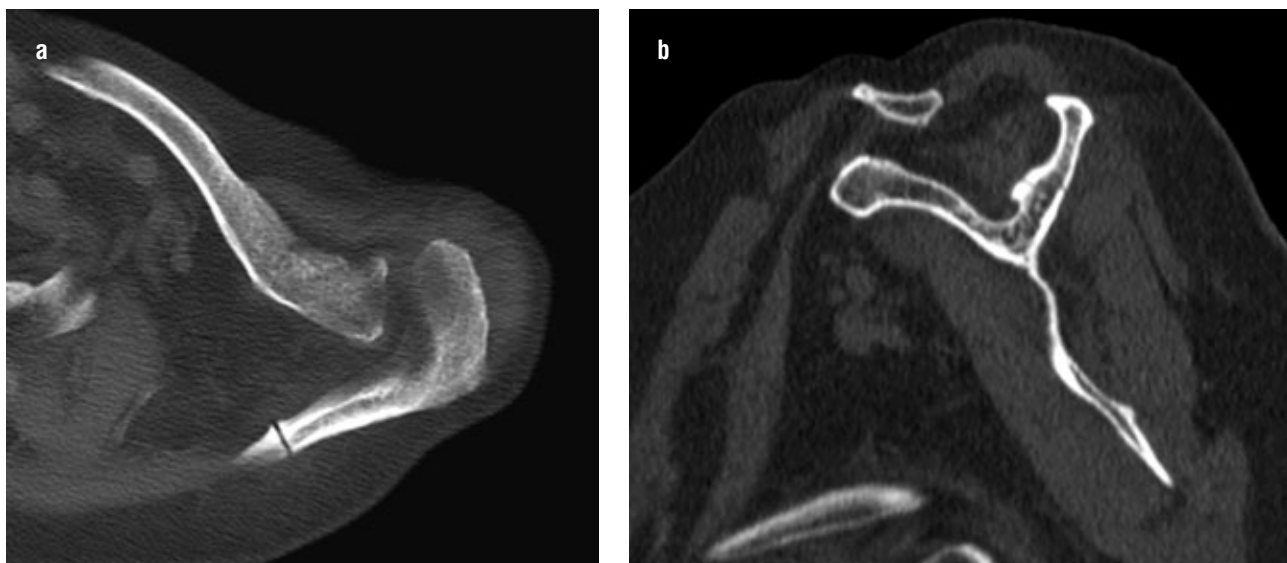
Scapular spine stress fracture on CT.
